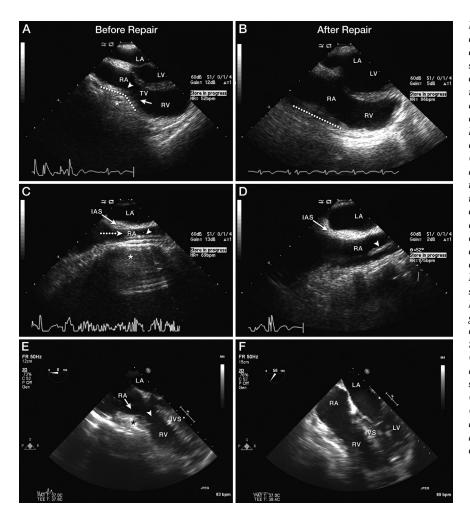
Intraoperative transesophageal echocardiography was performed both after induction of anesthesia and at completion of surgical correction with confirmation of relief of cardiac compression. (A) Preoperative midesophageal (ME) 4-chamber transesophageal echocardiographic view showing compression of right atrium (RA) (arrowhead) and right ventricle (RV) (arrow) caused by the pectus excavatum (PE) (asterisk). The dotted lines mark the PE angle. (B) Postoperative ME 4-chamber transesophageal echocardiographic view of the same patient showing considerable relief of right atrial and right ventricular compression. (C) Preoperative ME transesophageal echocardiographic view at level of interatrial septum (IAS) showing marked compression of RA (dotted arrow) caused by PE (asterisk). Swan-Ganz catheter can be seen in RA (arrowhead). (D) Postoperative ME 4-chamber transesophageal echocardiographic view at level of IAS showing relief of compression after surgical treatment of PE. Swan-Ganz catheter can be seen in RA (arrowhead). (E) Preoperative transesophageal echocardiographic ME view showing marked RA (arrow) and basal RV (arrowhead) compression by PE (asterisk). (F) Postoperative transesophageal echocardiographic ME view showing relief of RA and RV compression after surgical treatment of PE. (TV = tricuspid value.)
